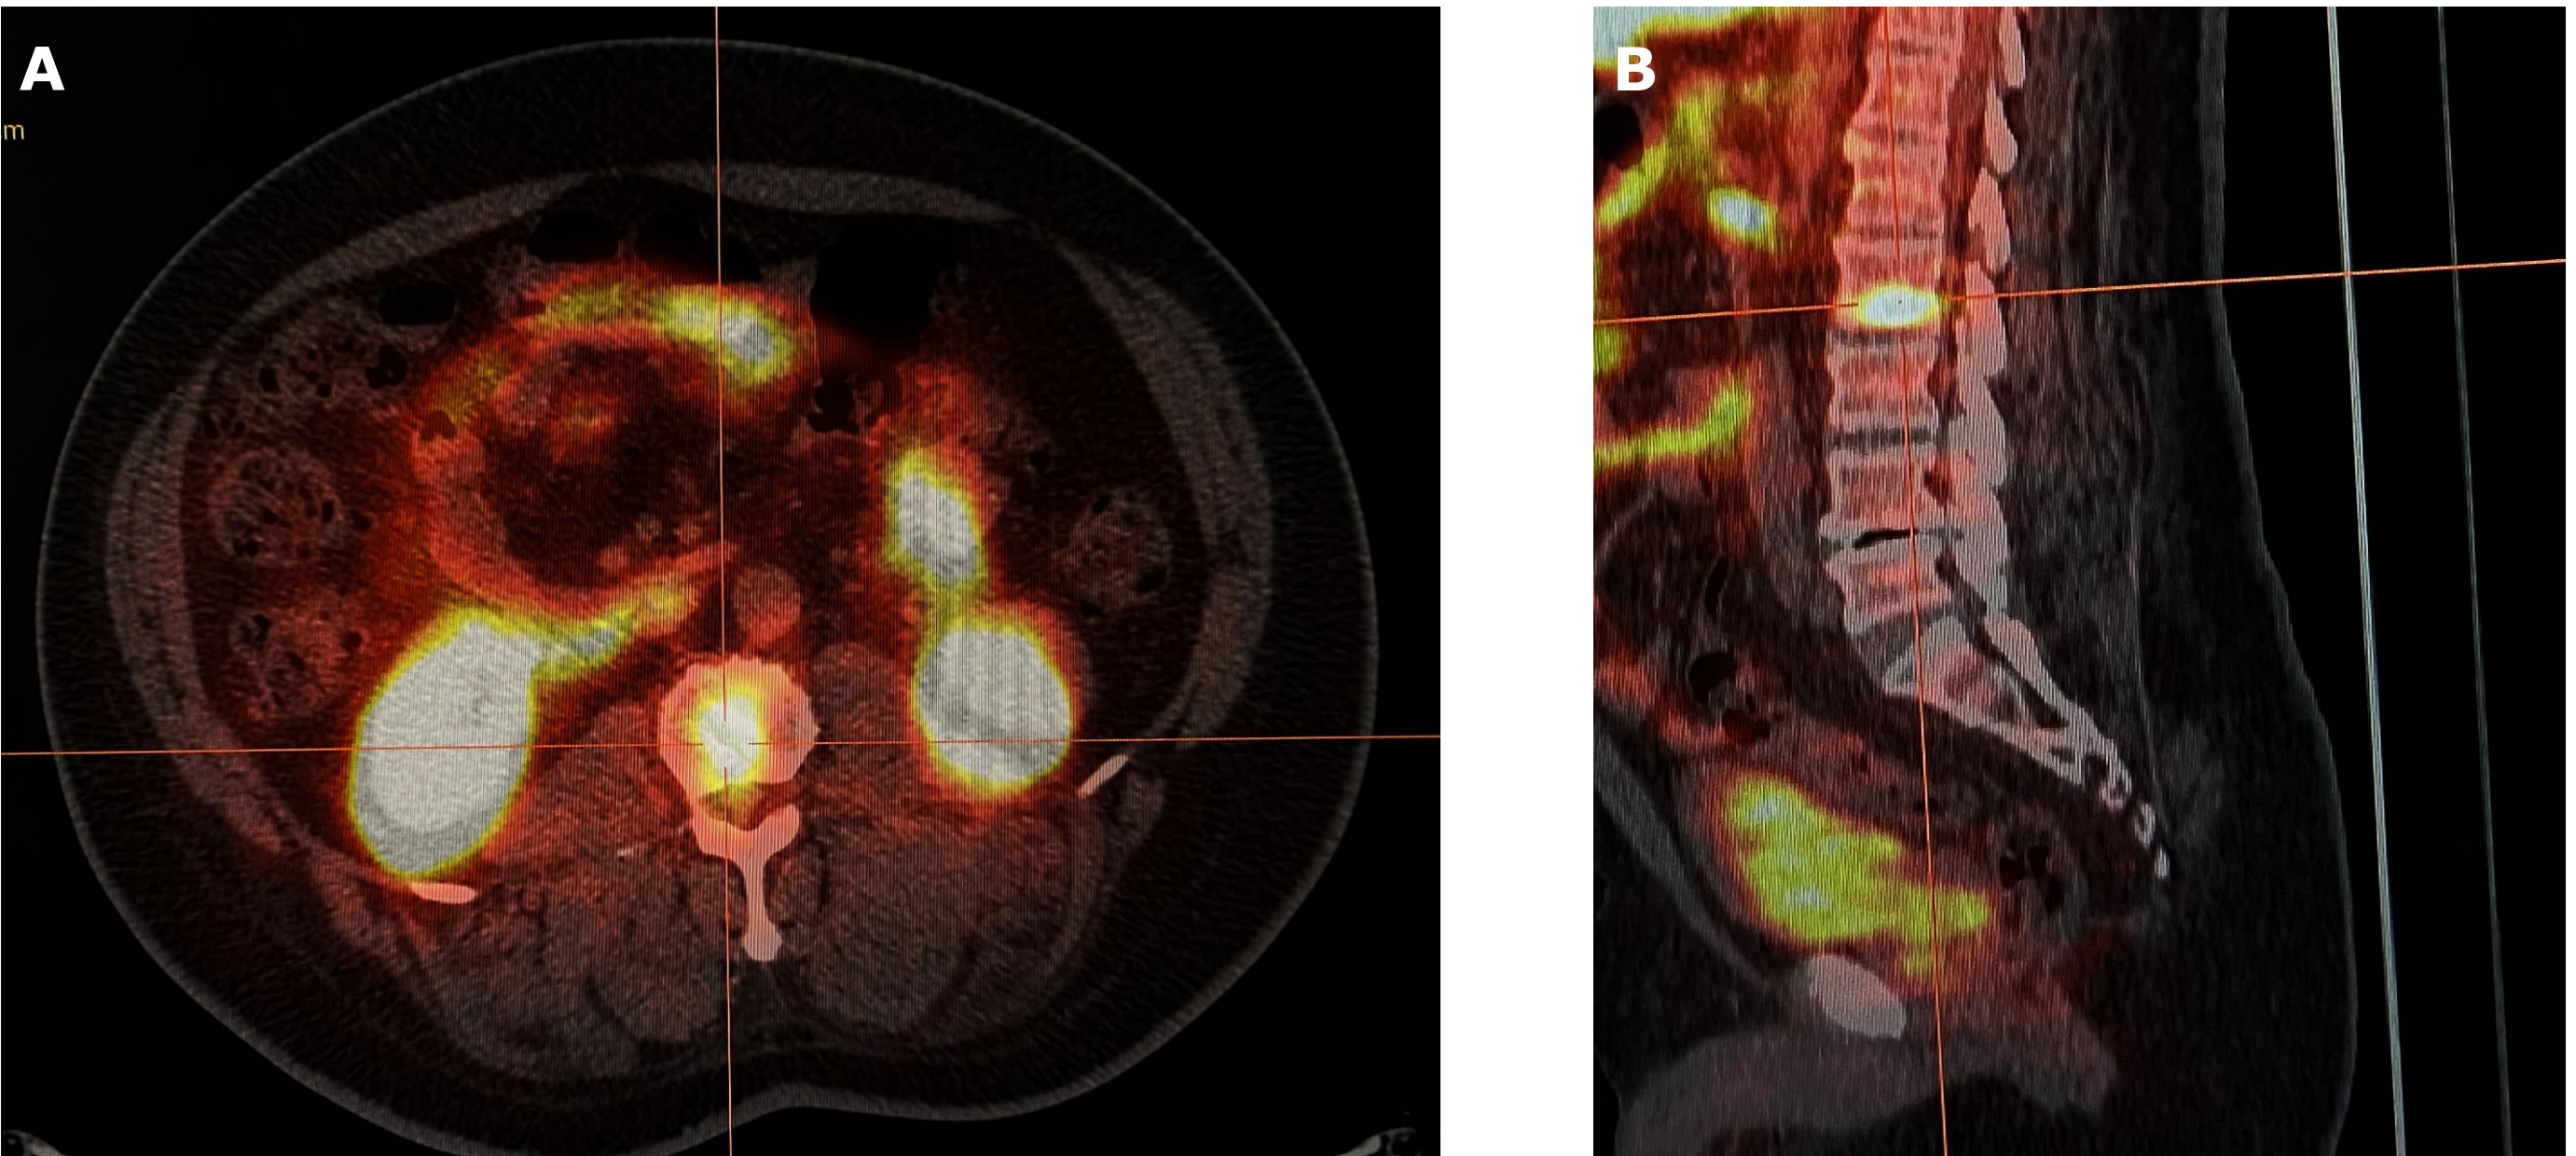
Axial (A) and sagittal (B) Pet-Scanner 18F-PSMA sections showing hypermetabolic damage to the vertebral body of L2
